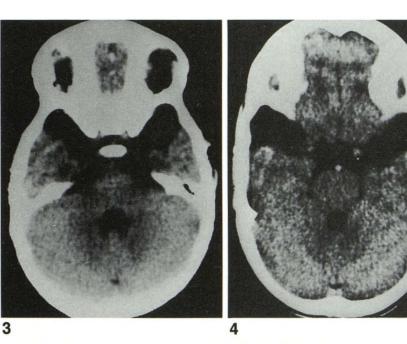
Case 4. Axial CT scan of 11-year-old brother of patient in case 3 shows same findings of fluid collections consistent with bilateral arachnoid cysts.
